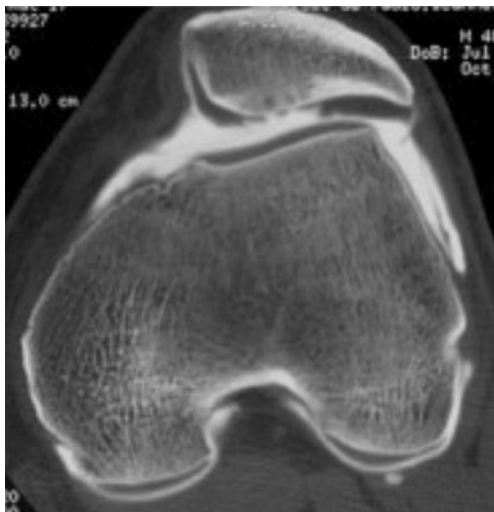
CT arthrogram demonstrating trochlear dysplasia
